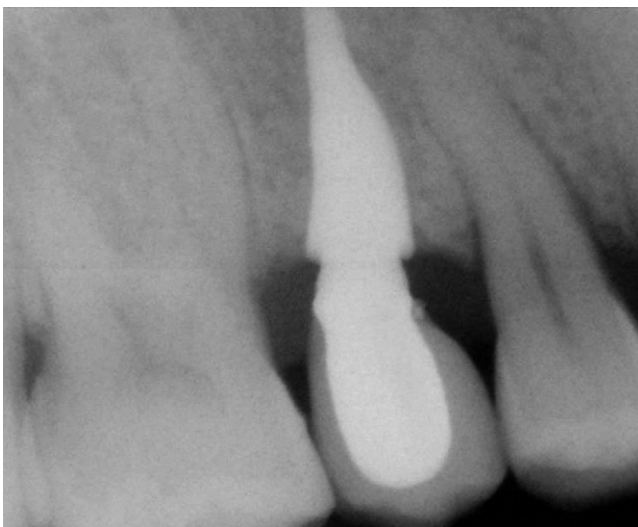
X-ray at 1-year follow-up with the custom-made RAI and crown *in situ*.
